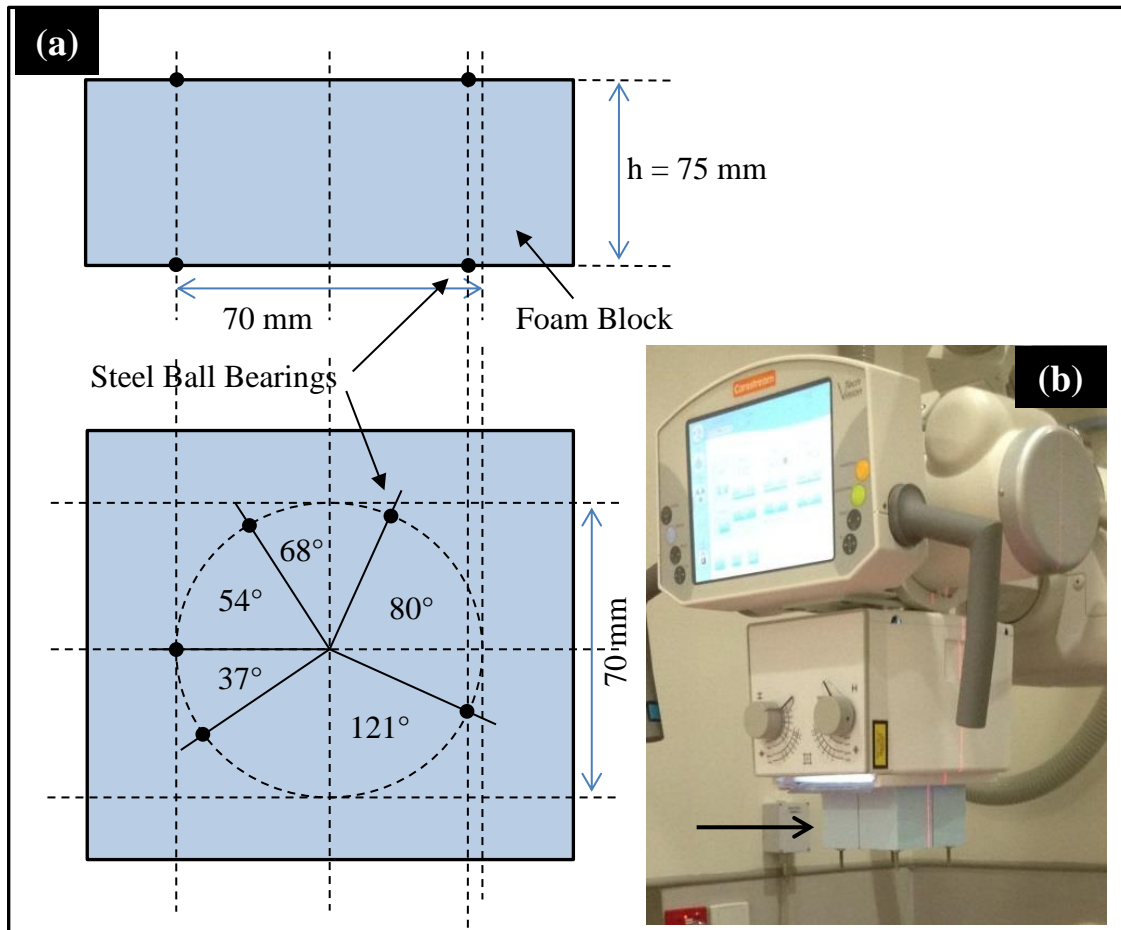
(a) The foam block holding the 3 mm diameter steel BBs arranged in a custom design on a 70 mm diameter circle. The positions of the BBs projected on the A-P image are such that when each BB pair is projected they do not meet an opposing BB pair line projection. (b) The BB array attached to the x-ray system collimator accessory tray.
